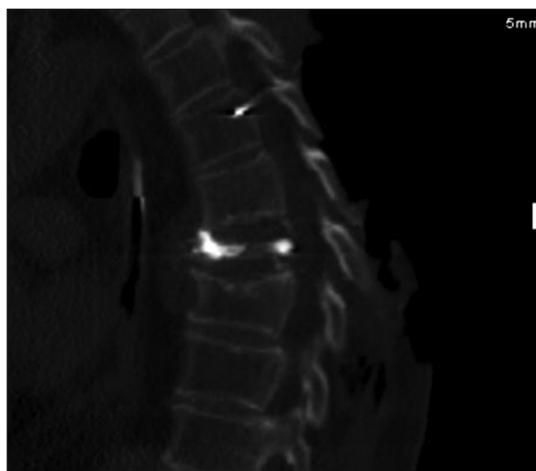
Sagittal computed tomography images of the thoracic spine status post T7 vertebroplasty.
